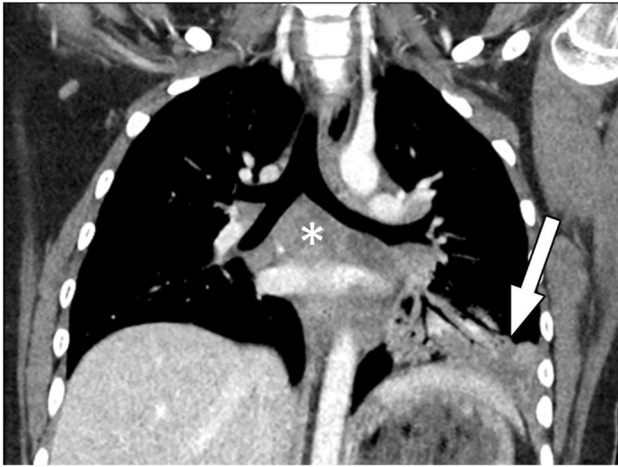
15-year-old girl with acute fungal infection due to coccidioidomycosis. Coronal reformatted chest CT image with IV contrast material shows left lower lobe consolidation (arrow) with air bronchograms. The hypoenhancement of the involved lung differentiates infectious consolidation from atelectasis (the majority of the left lower lobe opacity is hypoenhancing, whereas atelectasis should hyperenhance). Heterogeneously enhancing, mediastinal (asterisk) and hilar lymphadenopathy can also be seen
